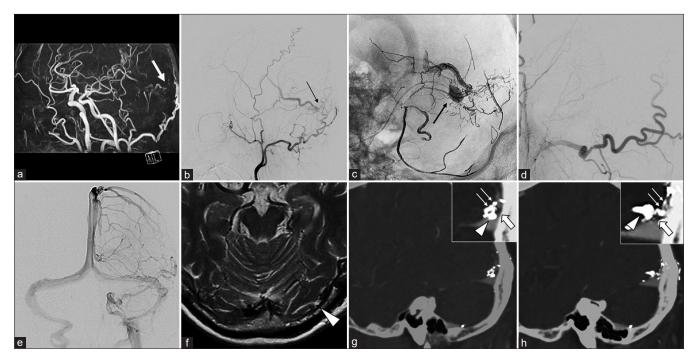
(a) A time-of-flight magnetic resonance angiography image demonstrates a left transverse-sigmoid dural arteriovenous fistula (DAVF) with cortical venous reflux (white arrow). (b) Left external carotid artery angiography (lateral view) demonstrates multiple feeding arteries of a DAVF from the mastoid branches of the occipital artery (OA) and petrosquamous branches of the middle meningeal artery directly draining into the vein of Labbe (VOL) (black arrow). The shunting point was suspected to be limited to the transverse sinus (TS) wall with no venous drainage into the dural sinus. (c) Transarterial Onyx embolization was performed through the mastoid branch of the OA with a DeFrictor microcatheter (Medico's Hirata, Osaka, Japan) and achieved successful penetration into the VOL. A SHOURYU HR (Kaneka Medics, Kanagawa, Japan) 7×7 -mm balloon catheter was placed on standby in the TS for Onyx penetration into the sinus; however, the shunting point was completely isolated from the TS (black arrow). (d) Final view after Onyx embolization; complete occlusion of the arteriovenous shunt. (e) The venous phase of internal carotid artery angiography demonstrates that the left TS was intact. (f) Heavy T2-weighted magnetic resonance imaging before Onyx embolization demonstrates the existence of arachnoid granulation (AG) in the shunting point of the left TS (white arrowhead). (g and h) The sagittal view of postoperative digital subtraction angiography and computed tomography fusion image shows that the Onyx cast demonstrated that multiple feeders (white arrows) aggregated into the AG (white arrow) and a dilated draining vein launched from the shunt point (white arrowhead).
